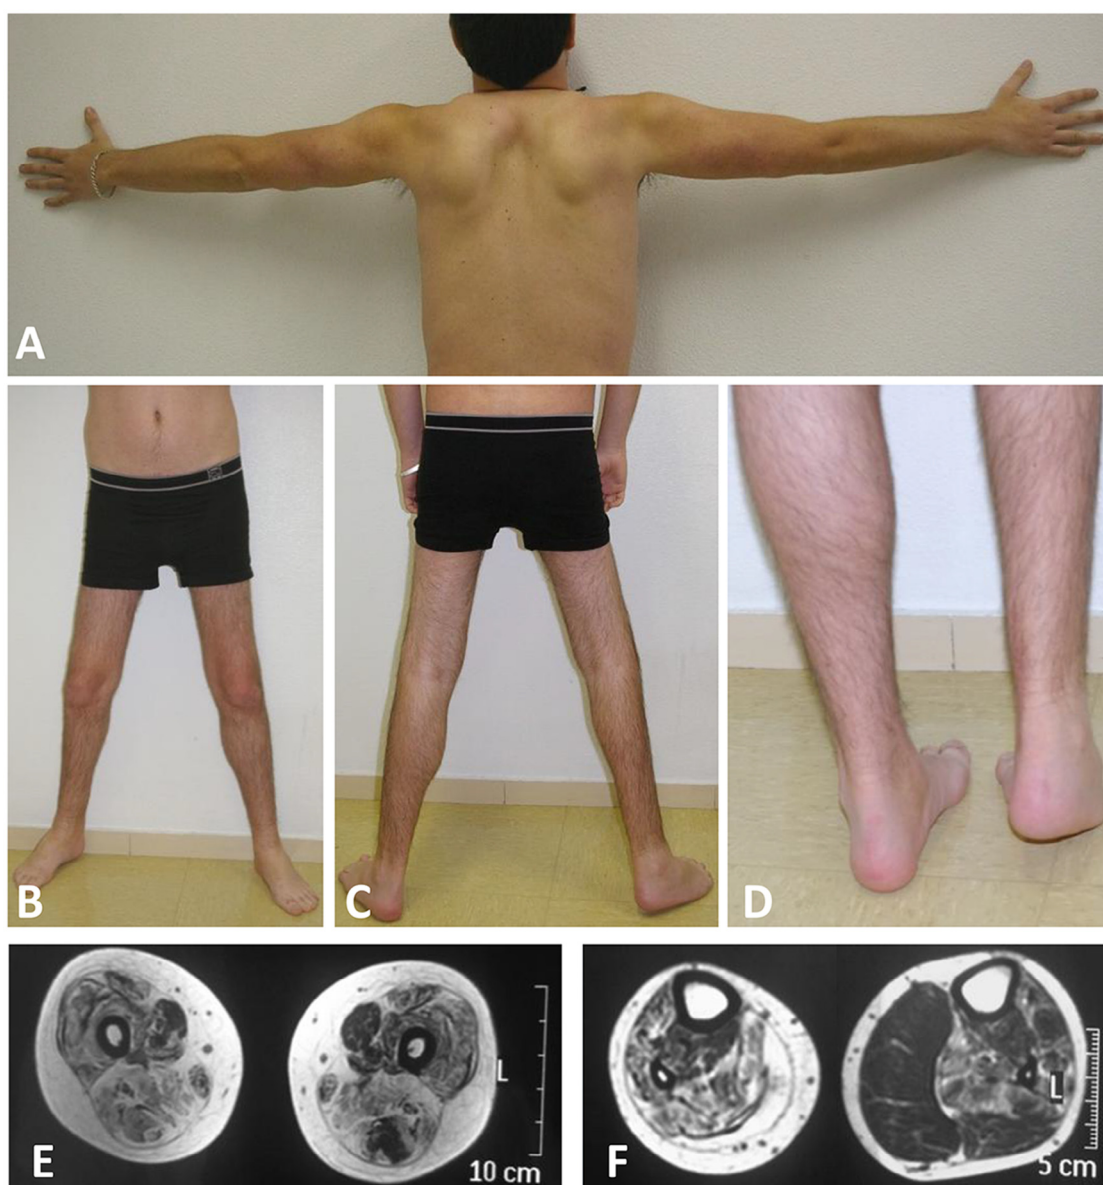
A–D: clinical phenotype of the patient. A: bilateral scapular winging. B–D: atrophy of the anterior and posterior thigh muscles and anterior tibialis. Asymmetric calves. Shorten of the right Achilles tendon. E–F: T-1 weighted MRI. E: Thighs. Note the severe fatty infiltration of almost every muscle. Left biceps femoris and right sartorius are less affected. Left sartorius is spared and hypertrophic. F: Legs. Tibialis anterior, soleus, peroneus longus and right gastrocnemii show a severe fatty infiltration. Left medial gastrocnemius is markedly hypertrophic.
